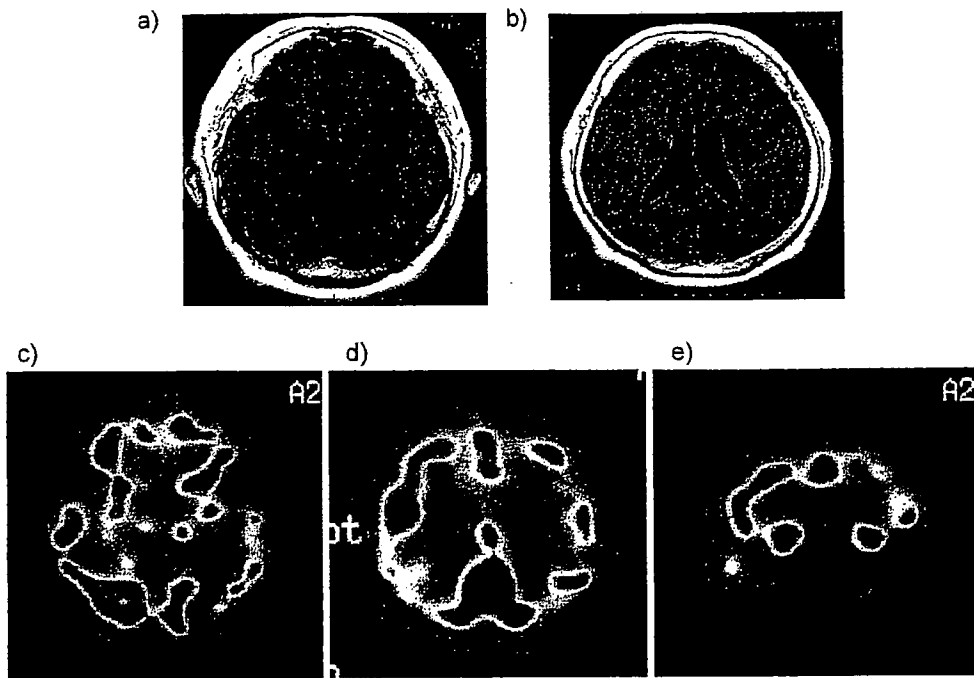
Brain MRI · SPECT
